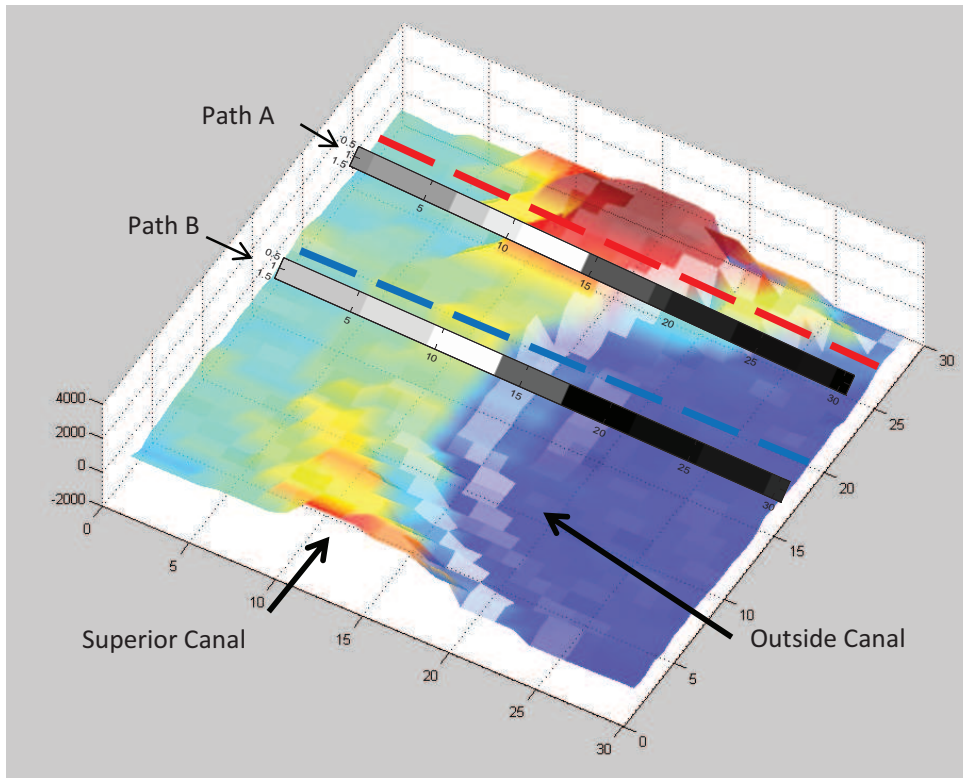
3D plot of intensity values of the CT scan. The view from above (lower plot) shows the circular shape of the superior canal. The red (path A) and blue (path B) lines correspond to the red and blue graph in (B) below. B The two lines as inserted in (A) plotted as HU intensity values. The black arrow in B shows that there is still a maximum which indicates that there is still bone over the canal and no dehiscence. No peak like this would be a hint for a dehiscence of the canal.
